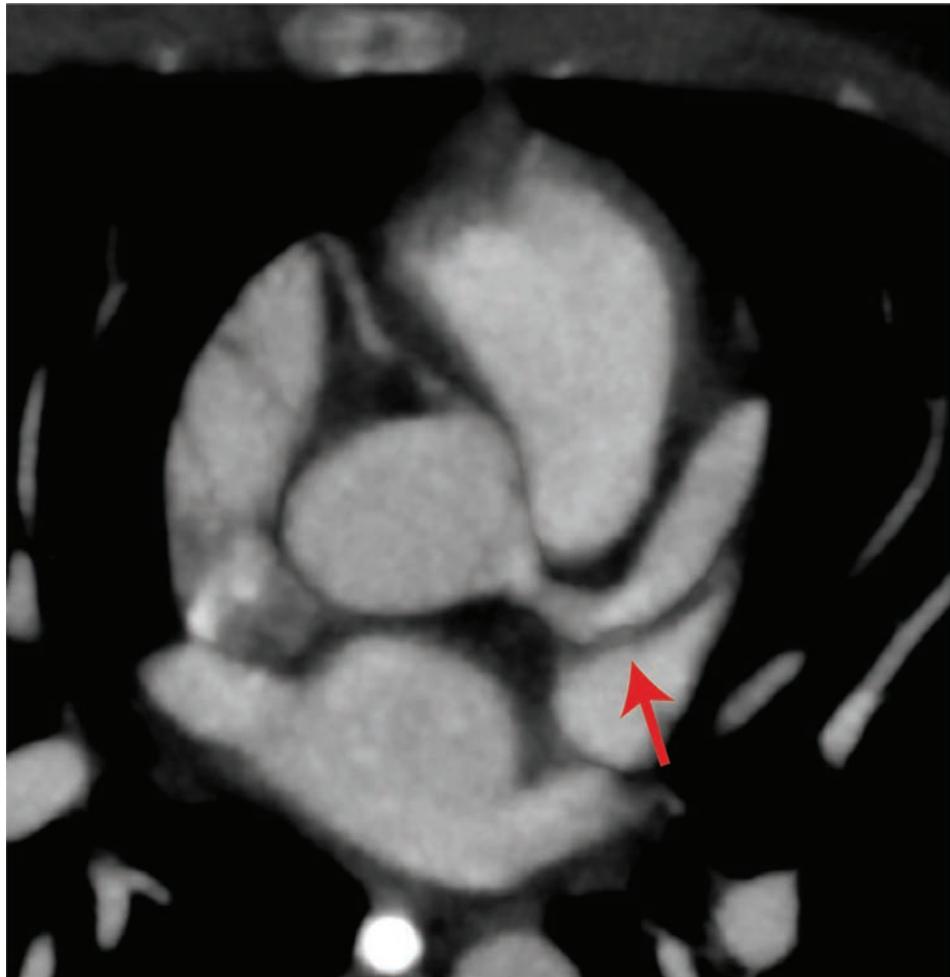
CTA of a patient with KD showing significant proximal dilation of the left coronary artery (arrow).
